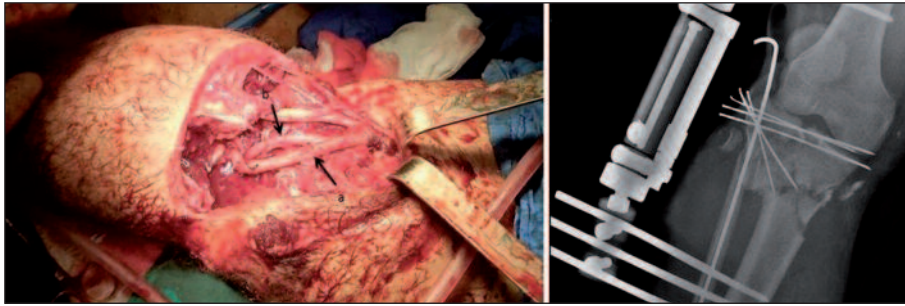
Perioperative vascular repair with saphenous vein interposition, and postoperative X-ray of our second case.
